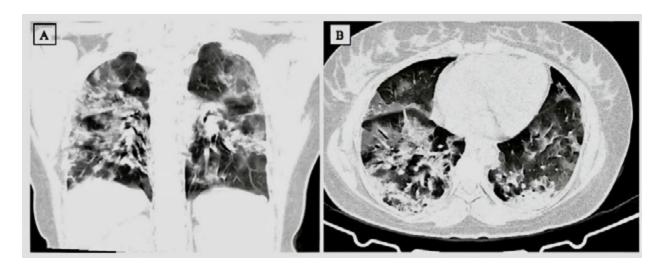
Chest computed tomography. A) Coronal view. B) Axial view. There is an accumulation of exudates in the alveolar cavity, vascular expansion, and exudation in the interstitium, consolidation demonstrating a large-scale fused alveolar lumen with air bronchogram inside.
